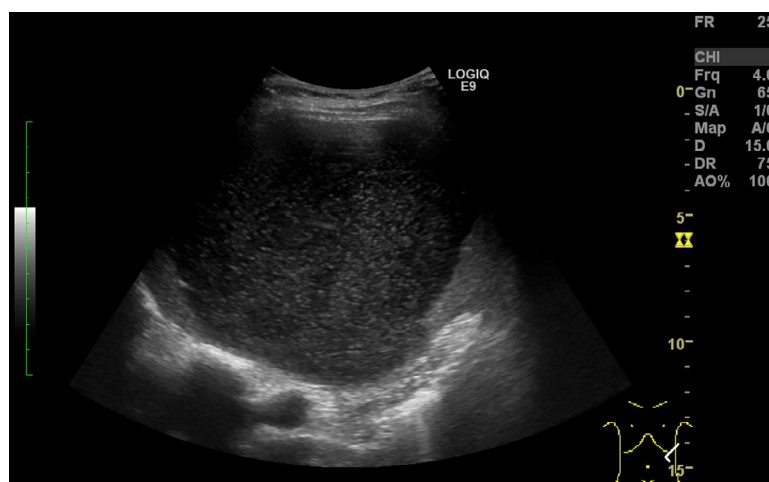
Ultrasound showing a unilocular cyst with multiple mobile internal echoes and liquid contents with posterior acoustic enhancement.
